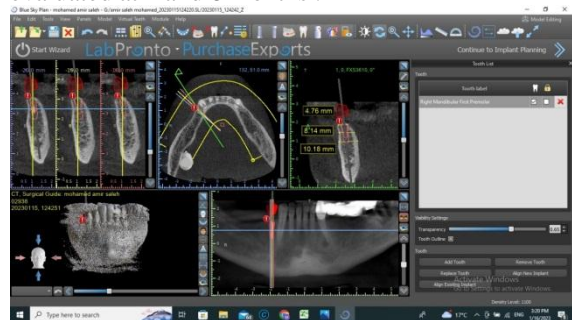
Pre operative CBCT with surgical planning and virtual implant placement with normal drilling protocol.
